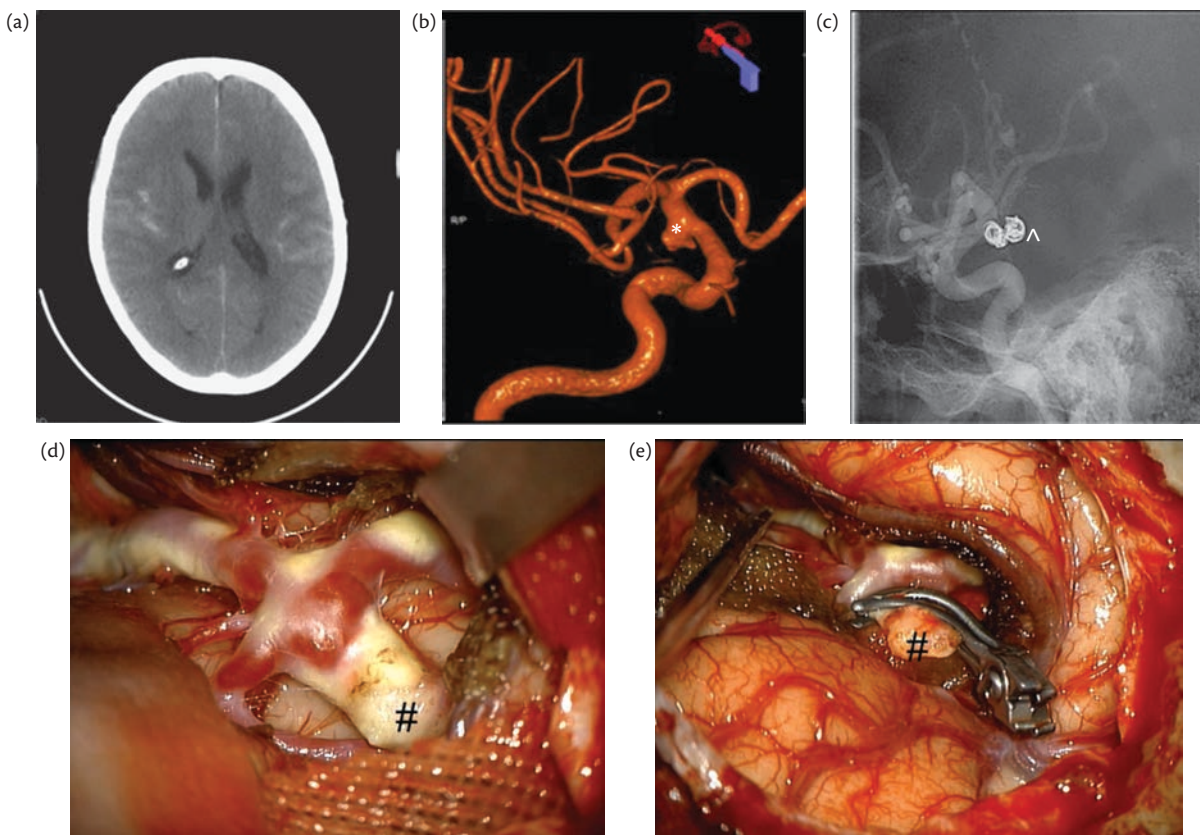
Treatment of aneurysms. (a) Non-contrast CT scan of a 67-year-old female presenting with subarachnoid haemorrhage. (b) 3D reconstruction of a digital subtraction angiogram demonstrating the right middle cerebral artery (MCA) bifurcation aneurysm (*) in the same patient. (c) Digital subtraction angiogram demonstrating the endovascular coiling of the same aneurysm (^). (d) Right MCA bifurcation aneurysm (#) during surgical treatment with subarachnoid haemorrhage. (e) Right MCA aneurysm post-placement of an aneurysm clip during the surgery.
